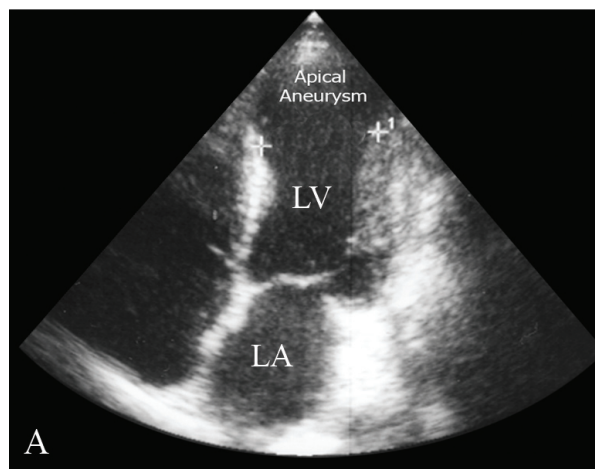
A. Preoperative echocardiography of the patient in the apical four-chamber view depicting the left ventricular apical aneurysm. B. Postoperative echocardiography in the same view showing elimination of the aneurysm after surgical plication
